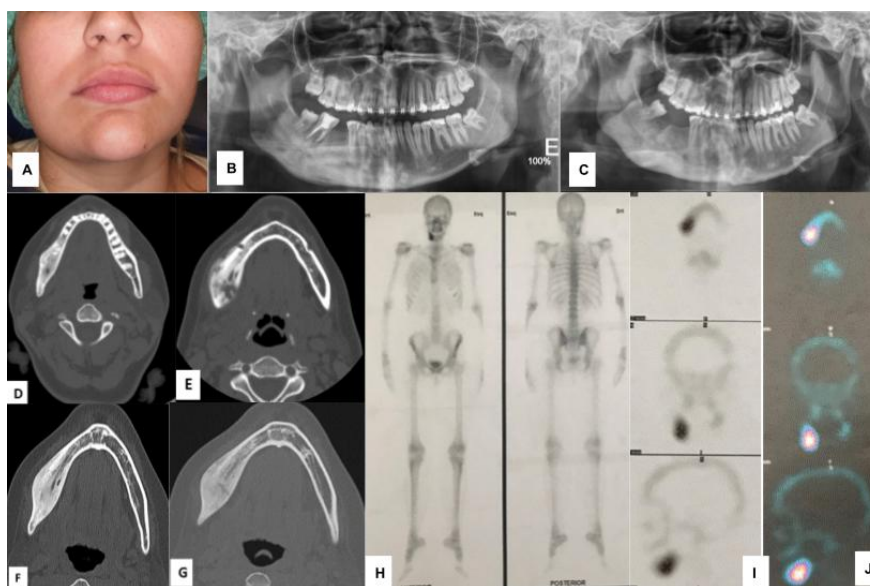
A - Right mandible region swelled. B and C - Orthopantomography before and after second molar extraction. D and E - Jaw Computer Tomography revealing exuberant periosteal reaction with progressive ossification of the right mandibular body. F and G - Jaw Computer Tomography revealing a layered bone sclerosis, resulting in a double contour of the mandible and facial asymmetry. H, I and J - Whole-body bone scintigraphy with head SPECT/CT showed focal hyperfixation in the right jaw.
